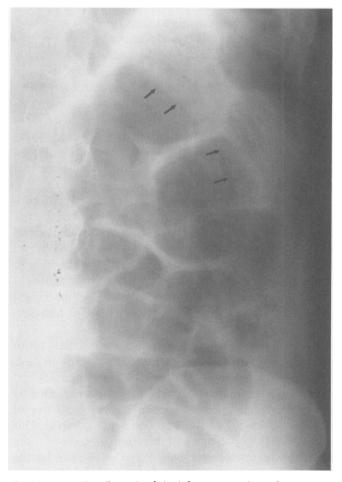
A coned radiograph of the left upper quadrant demonstrates subtle (1+) circumferential pneumatosis of jejunal segment. At surgery most of the jejunum and left colon were infarcted. The patient died 7 days after resection.
